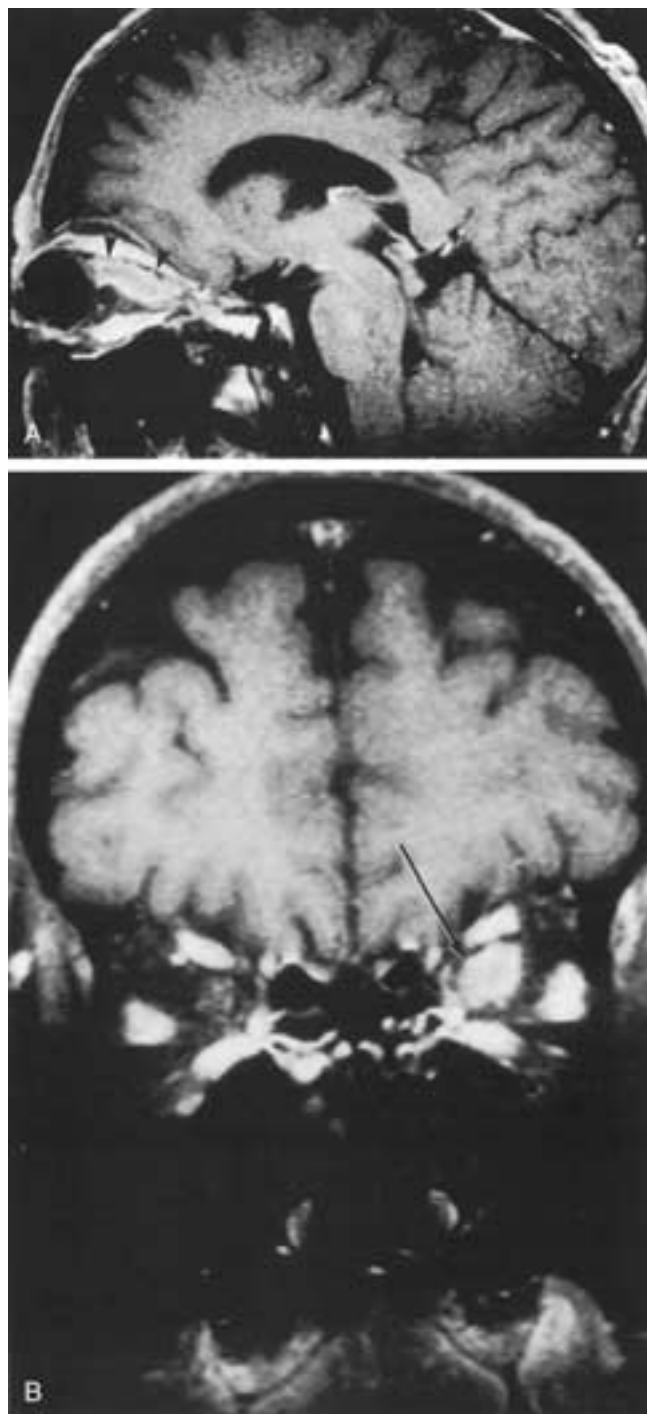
Perioptic meningioma in a 53-year-old male with left monocular visual loss and evidence of optic atrophy on fundoscopic examination. Symptoms had been progressive over a number of years. A, Oblique sagittal, fat-suppressed, gadolinium-enhanced T1-weighted MR image shows a mass (*arrowheads*) surrounding the optic nerve, extending from the globe back to the optic canal. B, Coronal fat-suppressed, T1-weighted, gadolinium-enhanced MR image shows that the left optic nerve (complex) is enlarged and enhancing (*arrow*).
